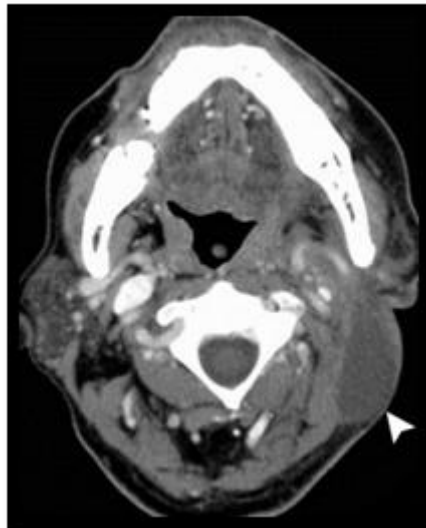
Serous retention in a 70-year-old man after a left-sided modified neck dissection with reconstruction with a pectoralis major pedicle flap. Axial contrast-enhanced CT image shows a fluid collection (arrowhead) adjacent to the flap, without rim enhancement. Follow-up imaging disclosed that the fluid eventually resorbed.
